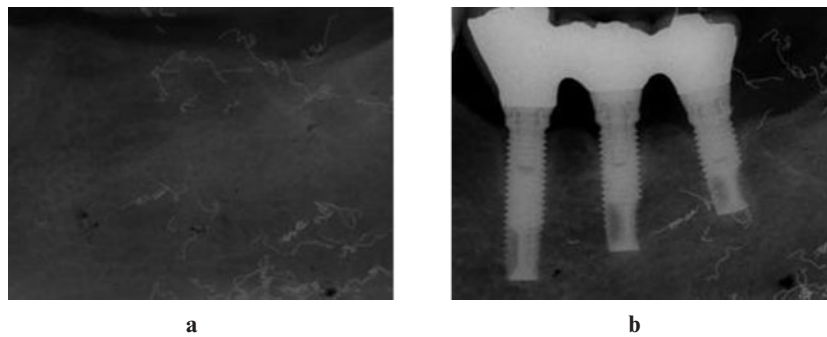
Intraoral radiographs of the mandibular left molar area (a) before and (b) after implant insertion
